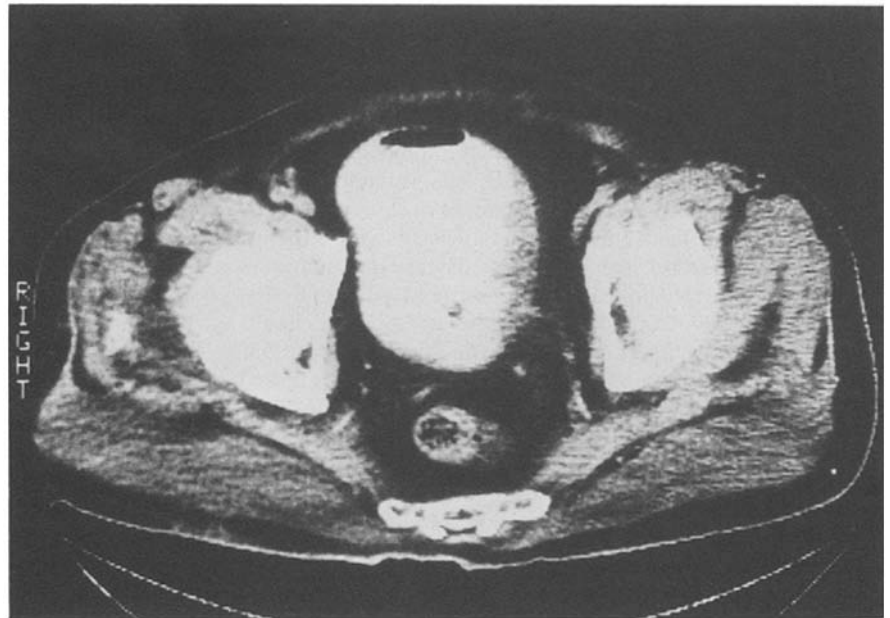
CT scan of case 13 after 2 months of inferior gluteal artery infusion chemotherapy revealed marked regression of the tumor
